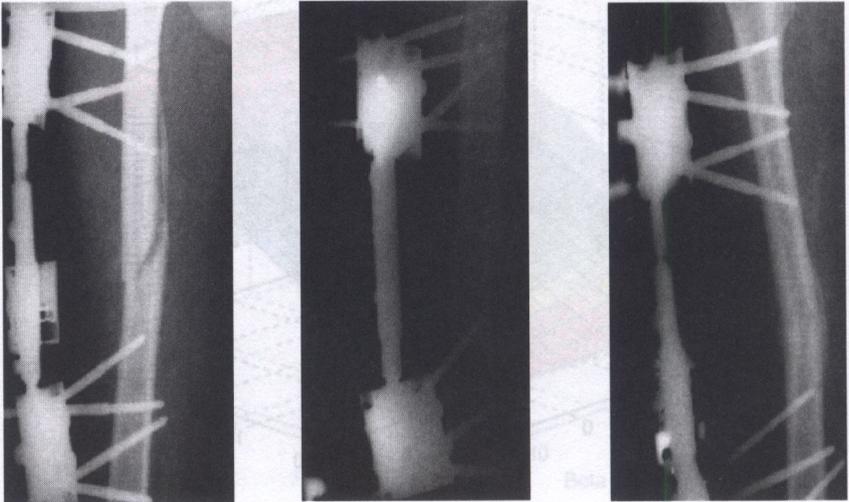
Radiographs of applications Dynastab-DK fixator for long bone fracture treatment (the X-ray pictures have been made available thanks to J. Deszczyński, the Czerniakowski Hospital in Warsaw, Poland).
